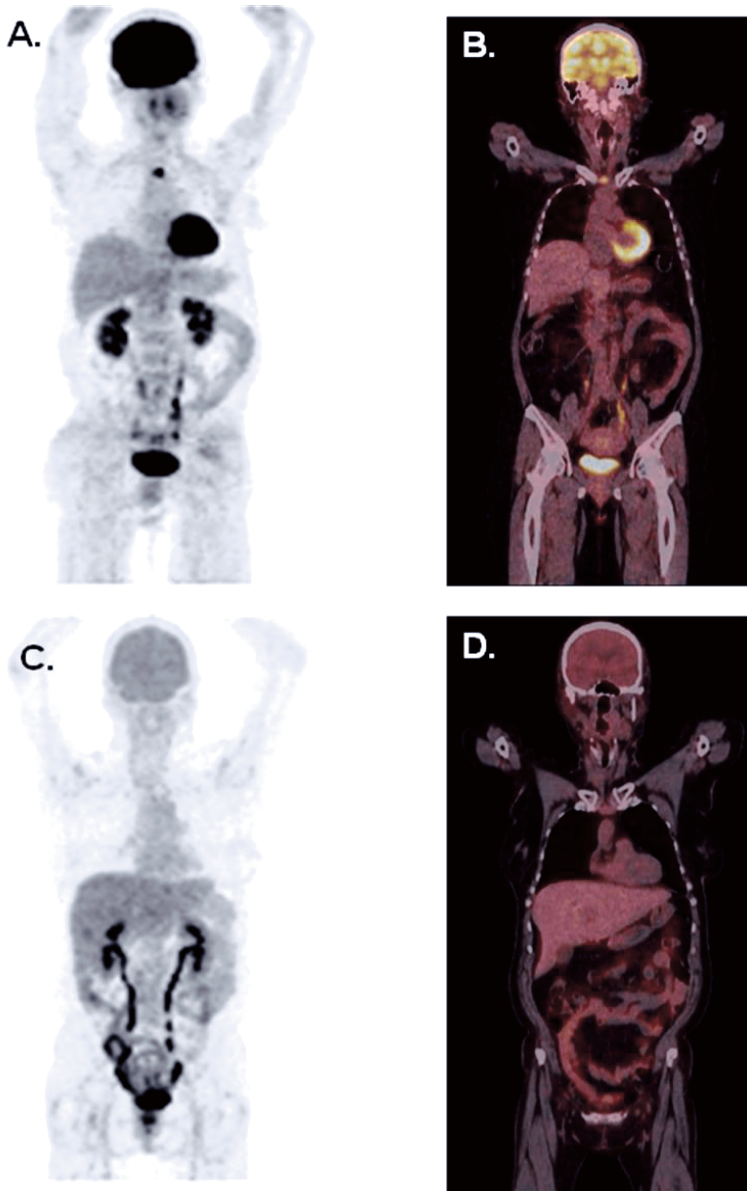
A-B: Female with DTC and increased Tg. Negative neck US and chest CT. FDG PET/CT identifies metastatic lymph node in upper anterior mediastinum (region VI). Blood glucose 5.4 mmol/L. A: Maximum intensity projections (MIP; PET-only). Normal brain intensity, frontal cortex SUV_{max}=15. Blood background SUV_{max}=2.1. C-D: Female with rectal cancer and diabetes mellitus type 2. Reduced FDG uptake in the brain caused by competitive uptake of high blood glucose 18.7 mmol/L. Tumor uptake was probably correspondingly reduced. FDG uptake in fat and muscle is typically low as well because of peripheral insulin resistance.
